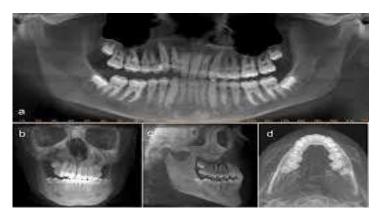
CBCT scan of the jaws courtesy:www.wikipedia/com
